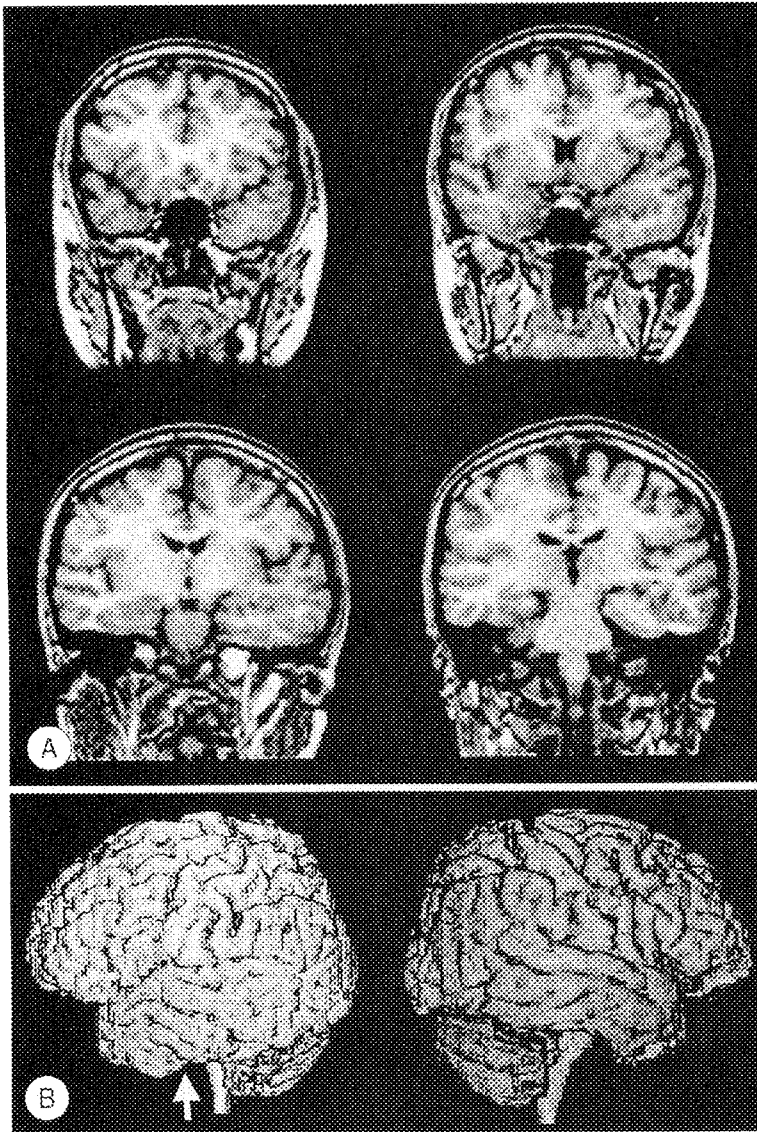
This patient had malformation in left mesial temporal region on 2D MRI (Fig-A). 3D rendering showed suicogyral anomaly (vertical complex gyral pattern in Fig-B) in left lateral temporal region which was not visualized in 2D MRI. Epileptogenic foci were found in both mesial and lateral temporal regions by invasive monitoring and epilepsy surgery.
